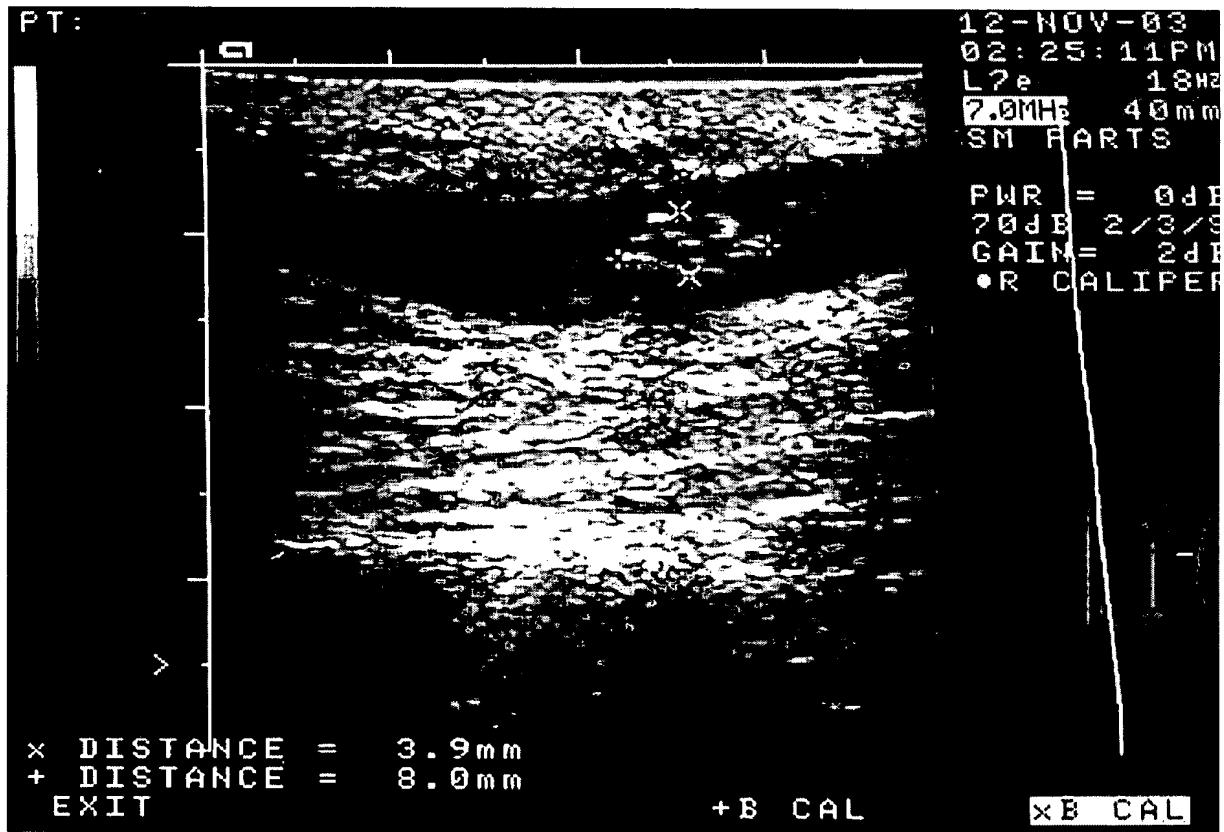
Versions of the ultrasonic scanning pattern on the site of insertion of B-16 cell culture, thickness of subcutaneous fat being up to 5mm.
